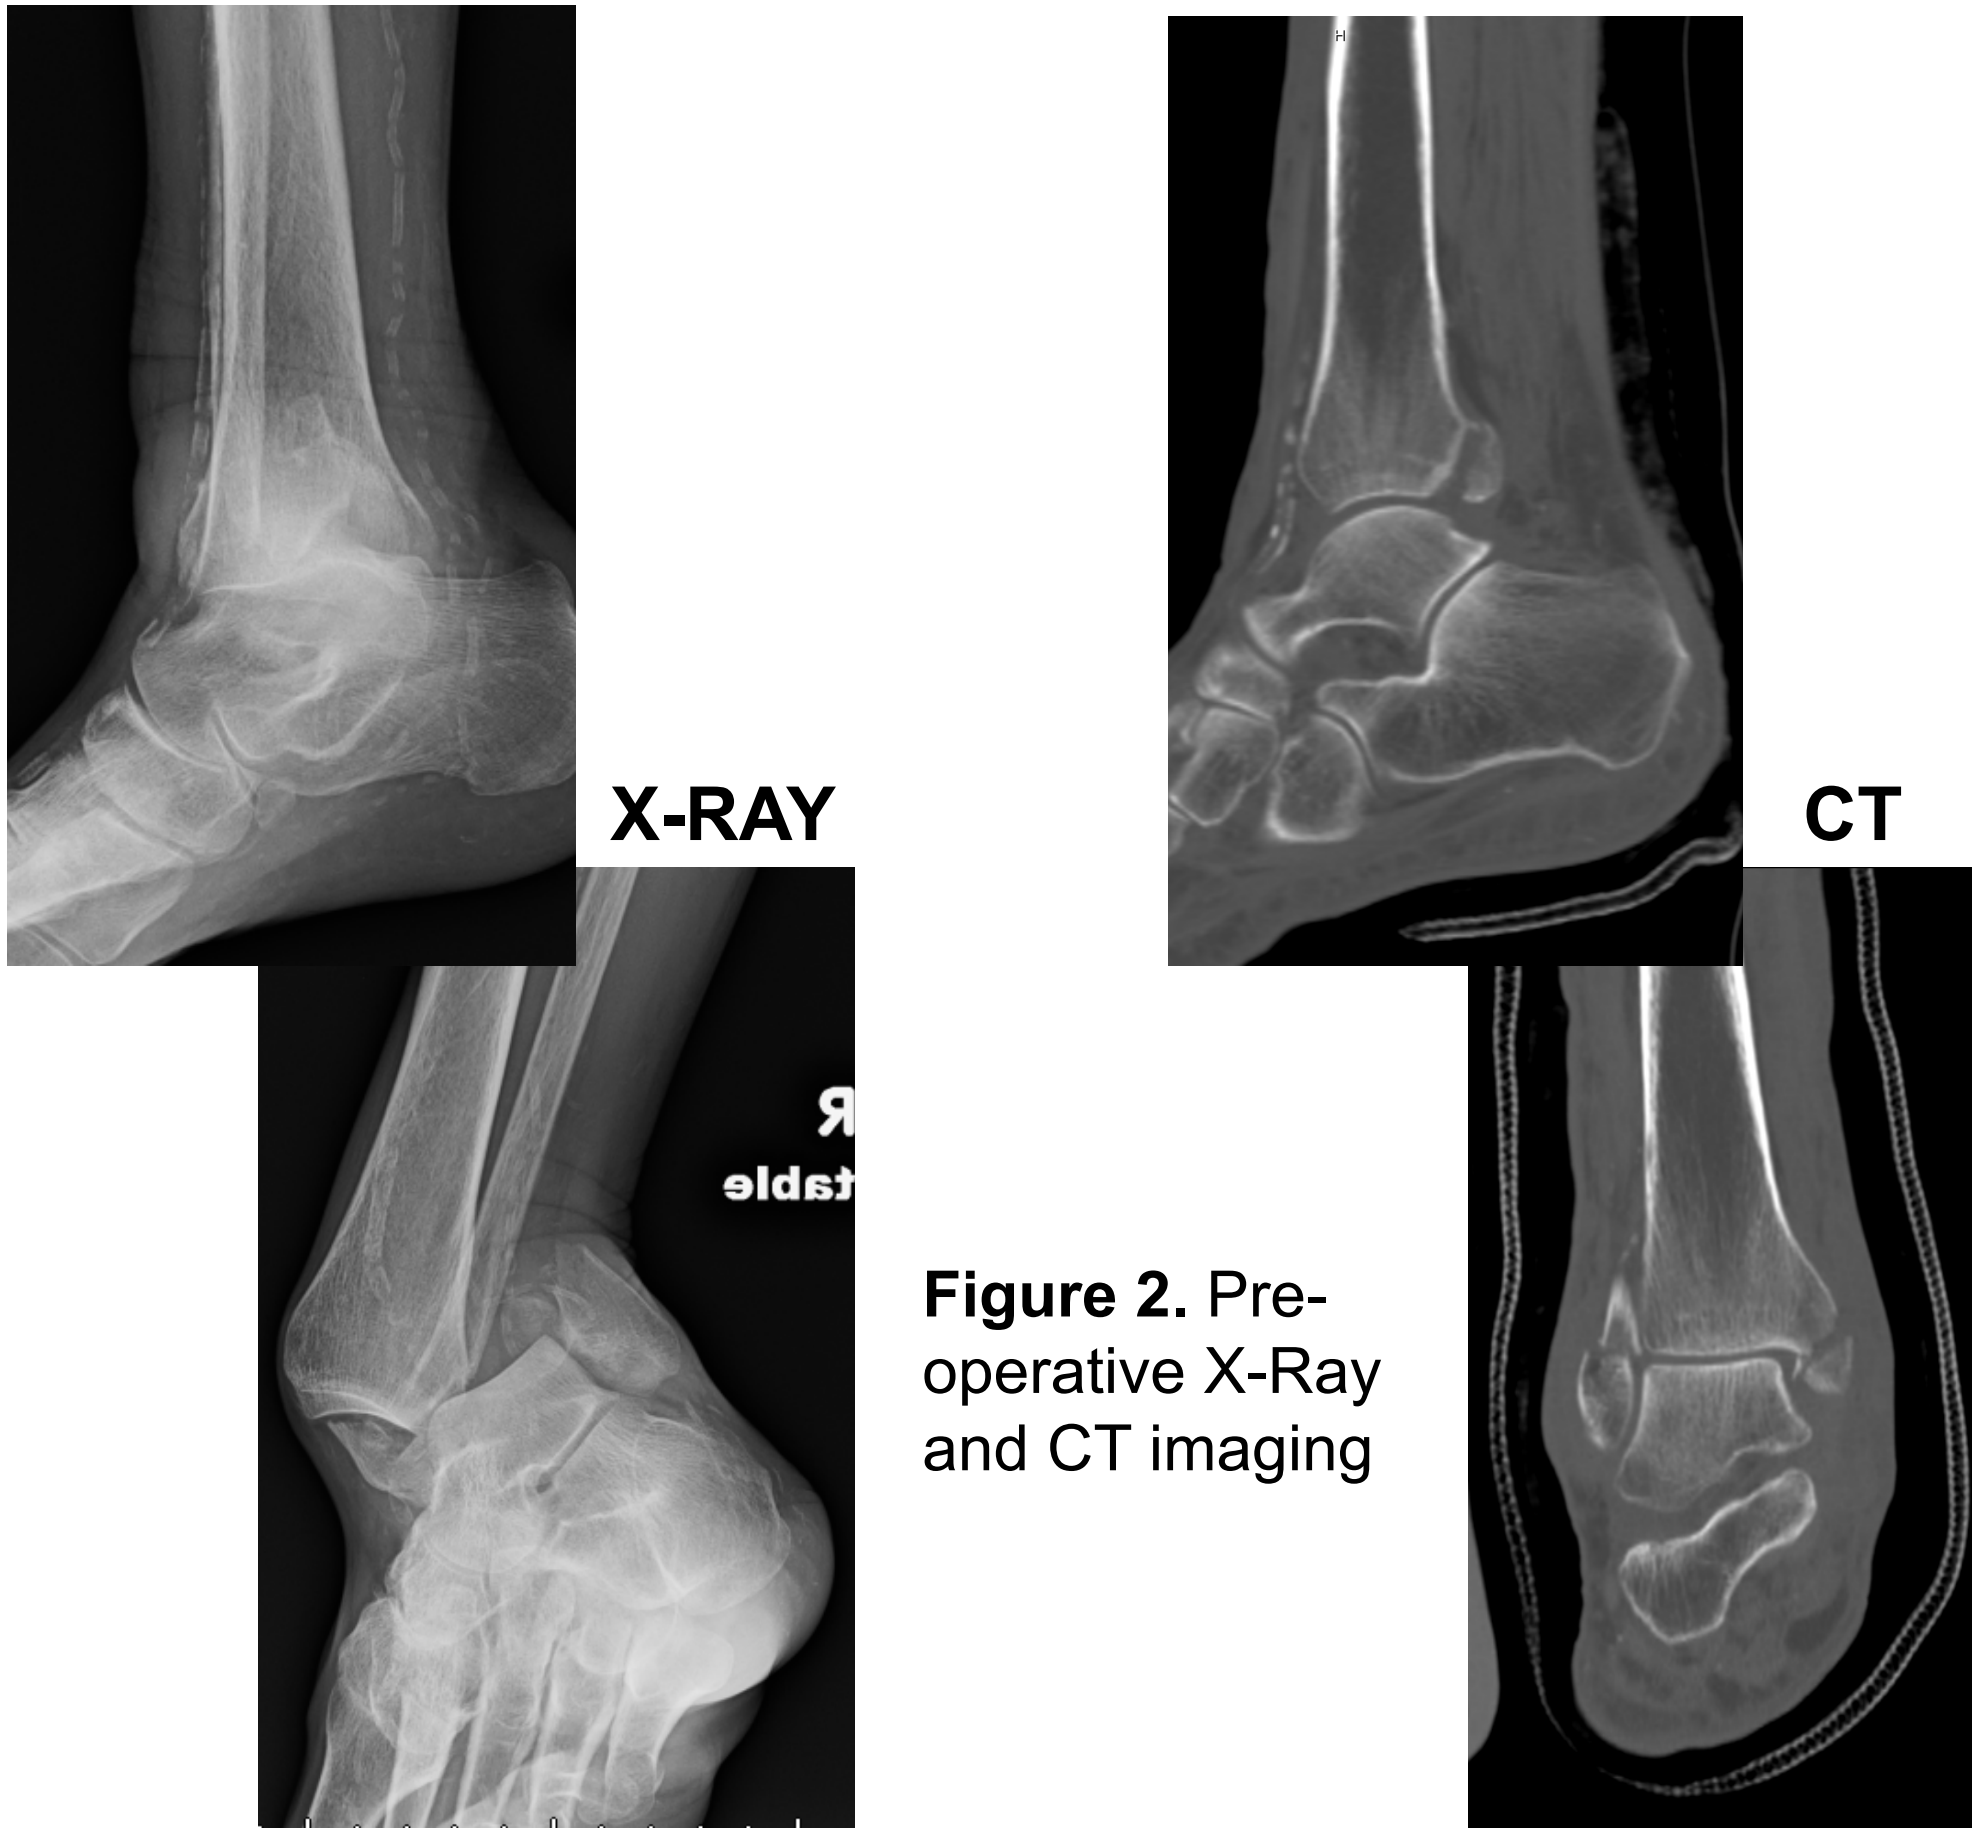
Pre-operative X-Ray and CT imaging
